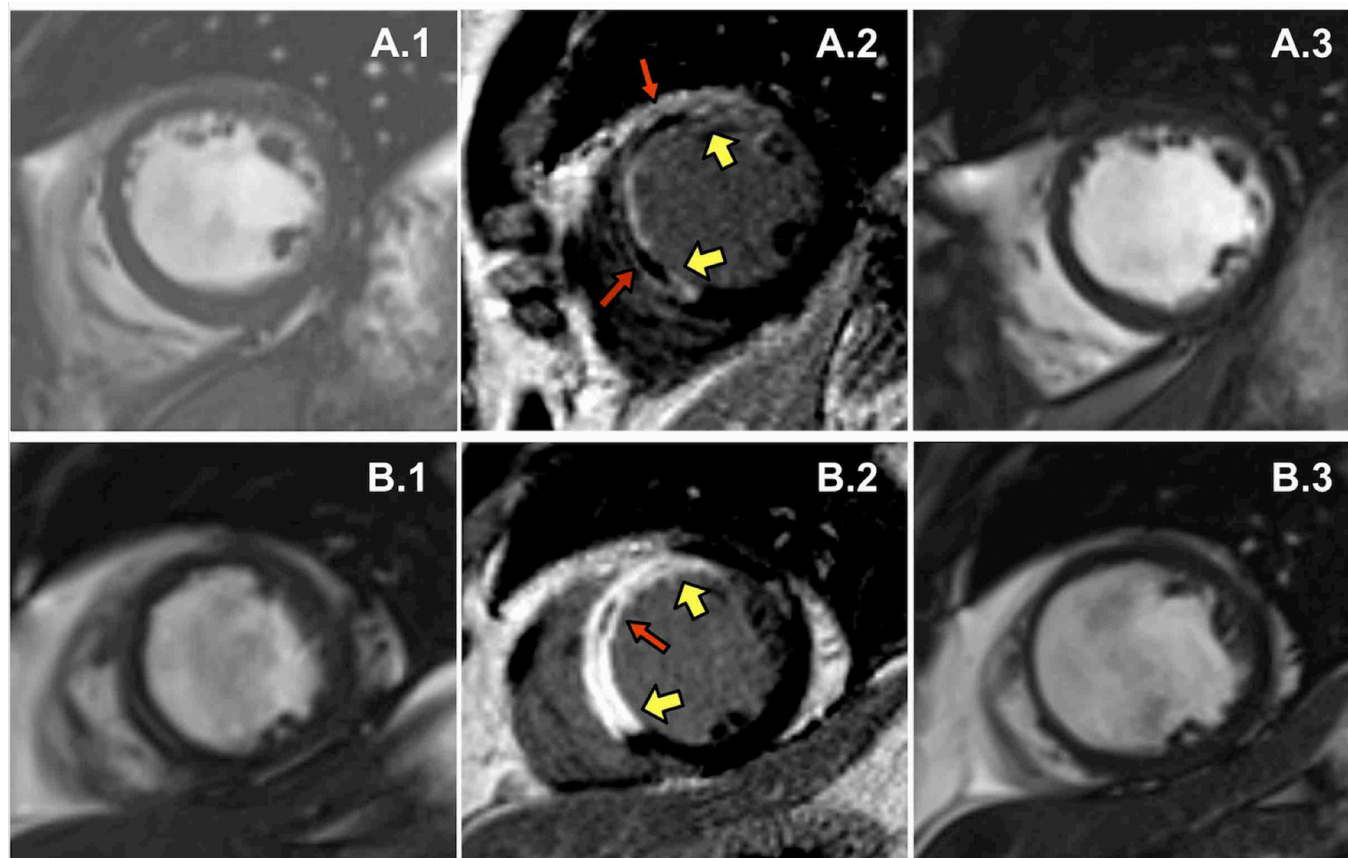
Similar presentations yet divergent outcomes. Two male patients presented with anterior ST-elevation myocardial infarction (MI) and had primary angioplasty to their proximal left anterior descending artery. They were enrolled in the British Heart Foundation MR-MI study (ClinicalTrials.gov identifier NCT02072850). Patient A was a 56-year-old man, who had a symptom to balloon time of 209 min. MRI on day 2 revealed a left ventricular (LV) ejection fraction of 47.4%, and indexed LV end-diastolic volume of 85.6 mL/m². Infarct size (A.2, yellow arrows) at baseline was 34.9% LV mass. Microvascular obstruction (A.2, red thin arrows) was 2.89% LV mass. At 6 months of follow-up (A.3), his LV ejection fraction improved to 56.1%, with no significant change in indexed LV end-diastolic volume (88.3 mL/m²). Patient B was a 58-year-old man, who had a symptom to balloon time of 132 min. MRI on day 2 revealed an LV ejection fraction of 46.4%, and indexed LV end-diastolic volume of 98.2 mL/m². Infarct size at baseline was 32.4% LV mass. Microvascular obstruction (B.2, red thin arrow) was 0.08% LV mass. At 6 months of follow-up (B.3), his LV ejection fraction deteriorated to 36.9%, with adverse remodelling (indexed LV end-diastolic volume 126.4 mL/m²). He proceeded to have an internal cardiac defibrillator implanted for primary prevention.
